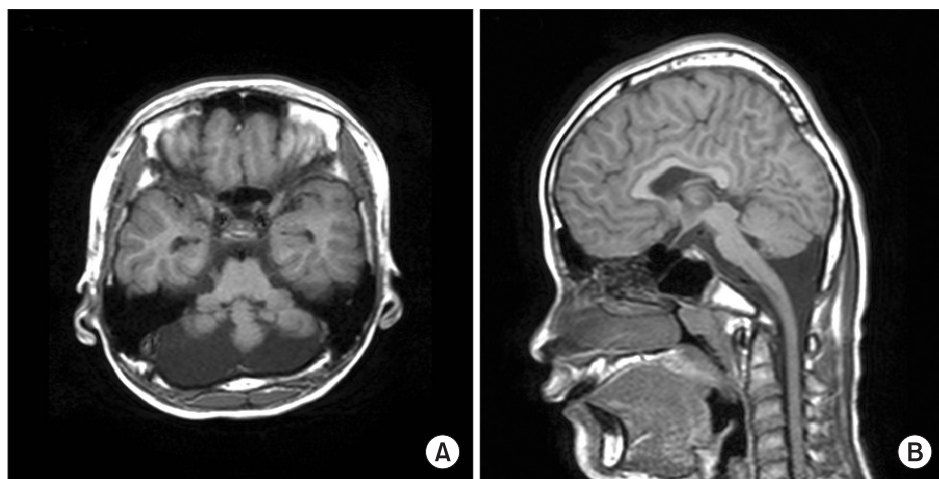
Brain magnetic resonance imaging shows (A) a cyst in the posterior fossa and hypoplasia of both cerebellar hemispheres, and (B) upward elevation of the hypoplastic cerebellar vermis due to the cyst.
